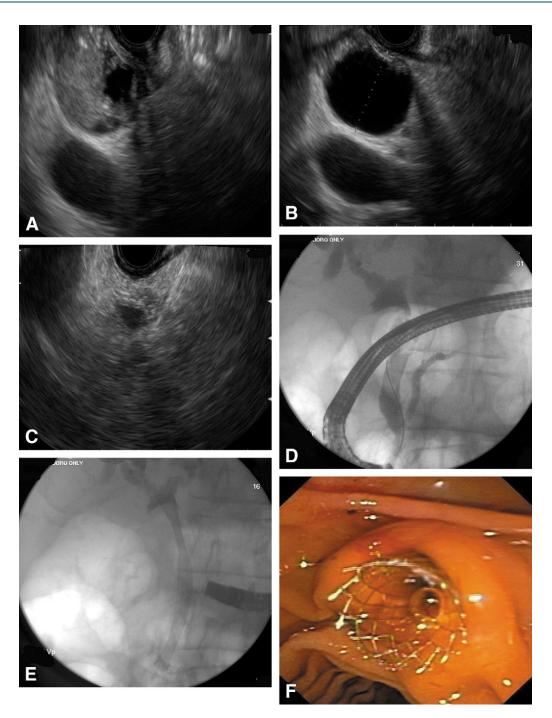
A, EUS showing a bile duct mass that was missed by a CT scan and magnetic resonance imaging. B, Biliary dilation was present proximal to the stenosis. C, EUS-FNA was performed and was diagnostic of cholangiocarcinoma. D, ERC was performed during the same session, and cholangiography revealed a distal biliary stricture. E, F, A self-expandable metal biliary stent was placed.
